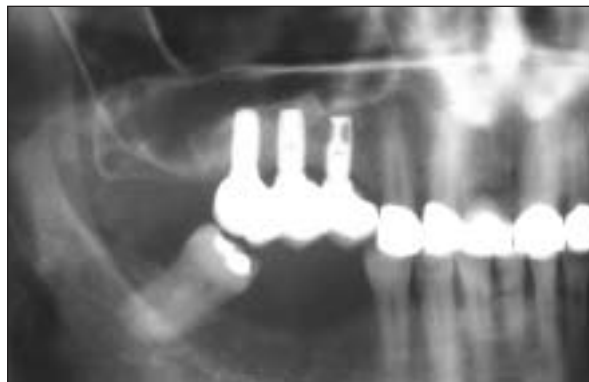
Radiograph 2 years post-loading of implants.
